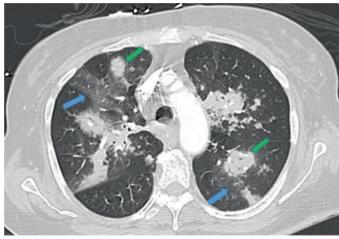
Cavitary nodular pneumonia caused by *Aspergillus*. A 34-year-old woman undergoing induction chemotherapy for newly diagnosed acute myeloid leukemia presents with persistent neutropenic fevers and cough productive of scant he moptysis. Sputum cultures are negative, but serum galactomannan antigen is markedly elevated, highly suggestive of *Aspergillus* infection. Computed tomography reveals multicentric cavitary nodules, some of which have a halo of ground-glass opacity. These findings are classic for invasive pulmonary aspergillosis.
